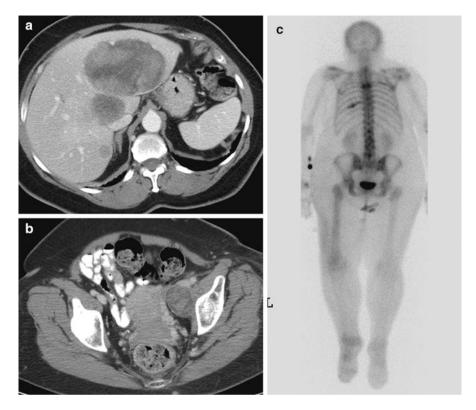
Axial CT (a, b) and PET scan (c) of metastatic pleomorphic liposarcoma to liver, retroperitoneum, and bone
